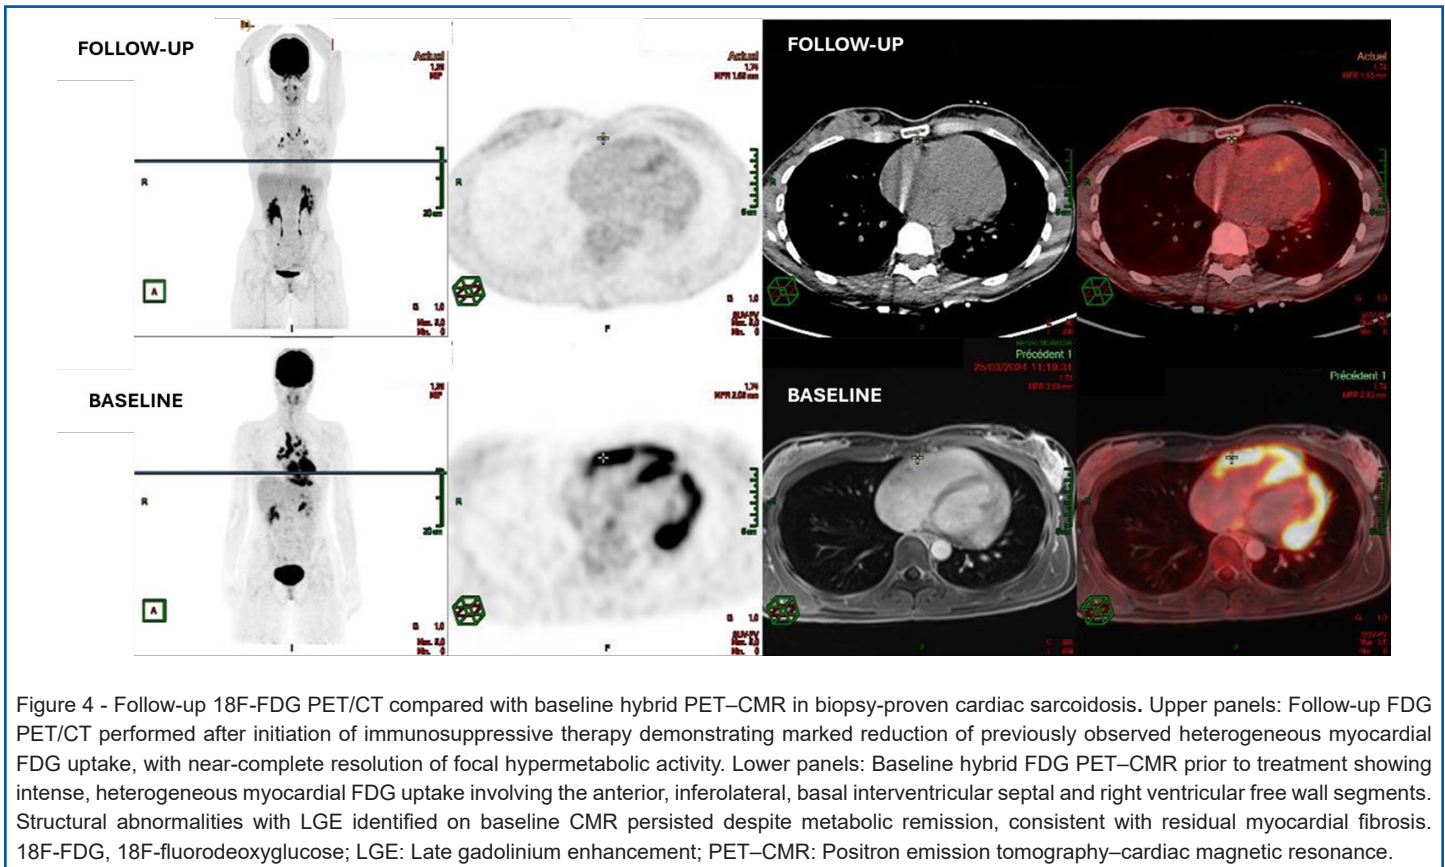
Follow-up 18F-FDG PET/CT compared with baseline hybrid PET-CMR in biopsy-proven cardiac sarcoidosis. Upper panels: Follow-up FDG PET/CT performed after initiation of immunosuppressive therapy demonstrating marked reduction of previously observed heterogeneous myocardial FDG uptake, with near-complete resolution of focal hypermetabolic activity. Lower panels: Baseline hybrid FDG PET-CMR prior to treatment showing intense, heterogeneous myocardial FDG uptake involving the anterior, inferolateral, basal interventricular septal and right ventricular free wall segments. Structural abnormalities with LGE identified on baseline CMR persisted despite metabolic remission, consistent with residual myocardial fibrosis. 18F-FDG, 18F-fluorodeoxyglucose; LGE: Late gadolinium enhancement; PET-CMR: Positron emission tomography-cardiac magnetic resonance.
